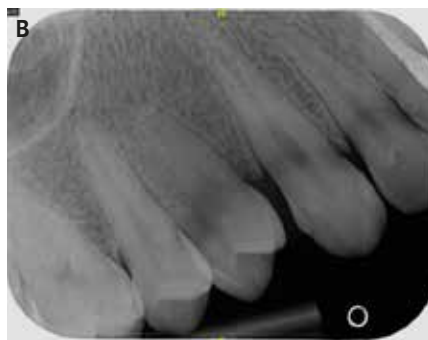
Figure (A) is an orthopantomograph. Figure (B) is a periapical radiograph of the upper right region. Both views show no significant findings and are consistent with PGCG.
